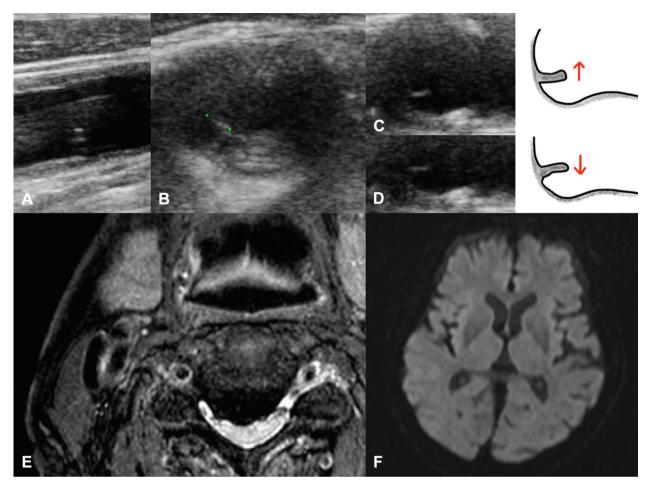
Preoperative images (carotid artery ultrasound, and head and neck MRI). On carotid artery ultrasound, mobile plaques with a maximum diameter of 2.0 mm were observed (A–D), and a T1WI high-intensity lesion suggesting vulnerable plaques was present in the same region on neck MRI (E). No ischemic change was noted on head MRI (F).
